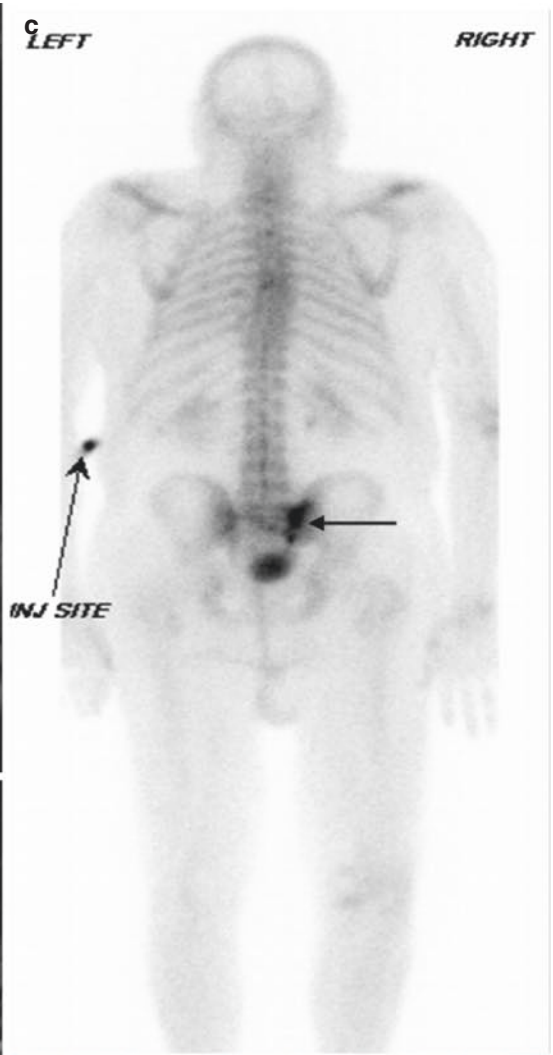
An 81-year-old male with low back and right leg pain. Fat-suppressed T2-weighted sagittal image (a) shows a marrow replacement process at S1 and S2 (arrows) and a ventral epidural soft tissue component (curved arrow). T1-weighted axial image (b) shows an infiltrative hypointense lesion within the right sacral ala (large arrow) and sacral vertebral body (small arrow) with a hypointense epidural soft tissue component (curved arrow). Single posterior projection (c) from a bone scan shows intense focal radionuclide uptake within the right
